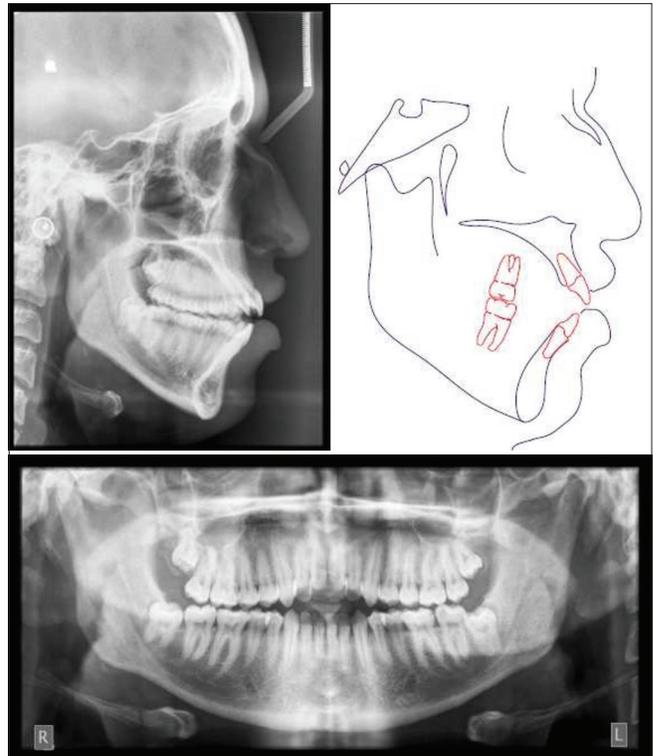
Pre-treatment lateral ceph with tracing and panoramic radiograph
